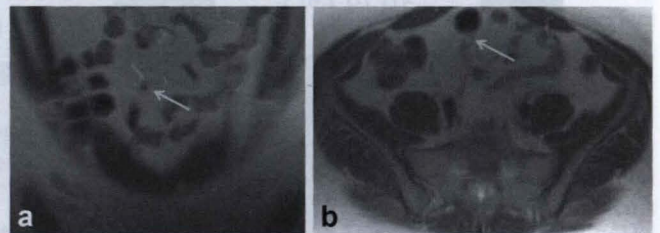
A 32 year-old female, 8 weeks gestation, presented with vague abdominal pain for 4 days. (a) Coronal and (b) axial MRI images demonstrate a minimally dilated (8 mm), fluid-filled appendix (arrow) with a small amount of periappendiceal fluid. This examination was interpreted as indeterminate by both reviewing radiologists and the original MRI report, and was categorized as a false-positive. This patient was admitted for short inpatient observation. Her symptoms improved without antibiotics, and a follow-up note showed that her abdominal pain had resolved.
